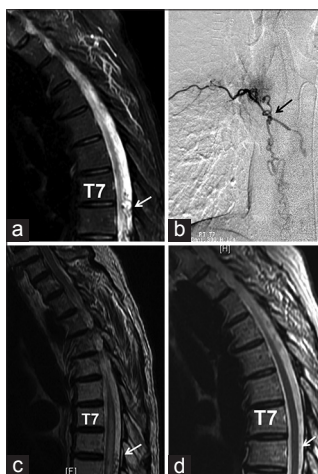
(a) Preoperative T2 magnetic resonance imaging (MRI) of patient 1 showing the serpiginous veins surrounding the thoracic spinal cord most prominent at T7/8 level (arrowed), secondary to the dural arteriovenous fistula (DAVF). (b) Preoperative super-selective angiography of patient 1 showing the DAVF fed by the right T7 radicular artery (arrowed). (c) Preoperative T2 MRI of patient 2 showing the serpiginous veins surrounding the thoracic spinal cord most prominent at T8/9 level (arrowed), secondary to the DAVF. (d) Postoperative T2 MRI of patient 1 showing the resolution of venous engorgement around the thoracic spinal cord (arrowed)
